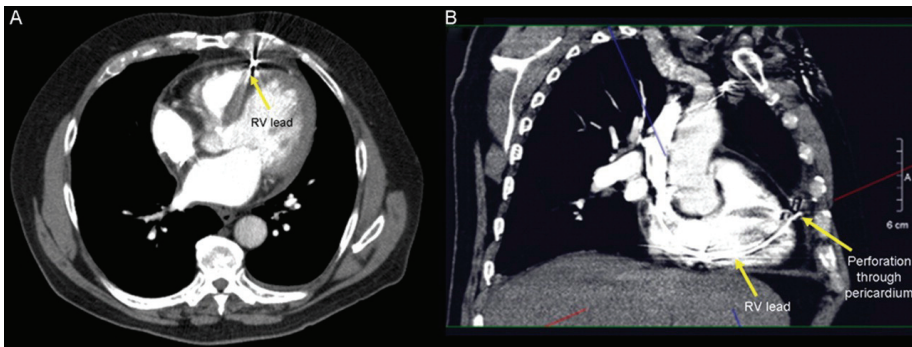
CT images of the thorax demonstrating right ventricular (RV) lead position and cardiac perforation by RV electrode.
